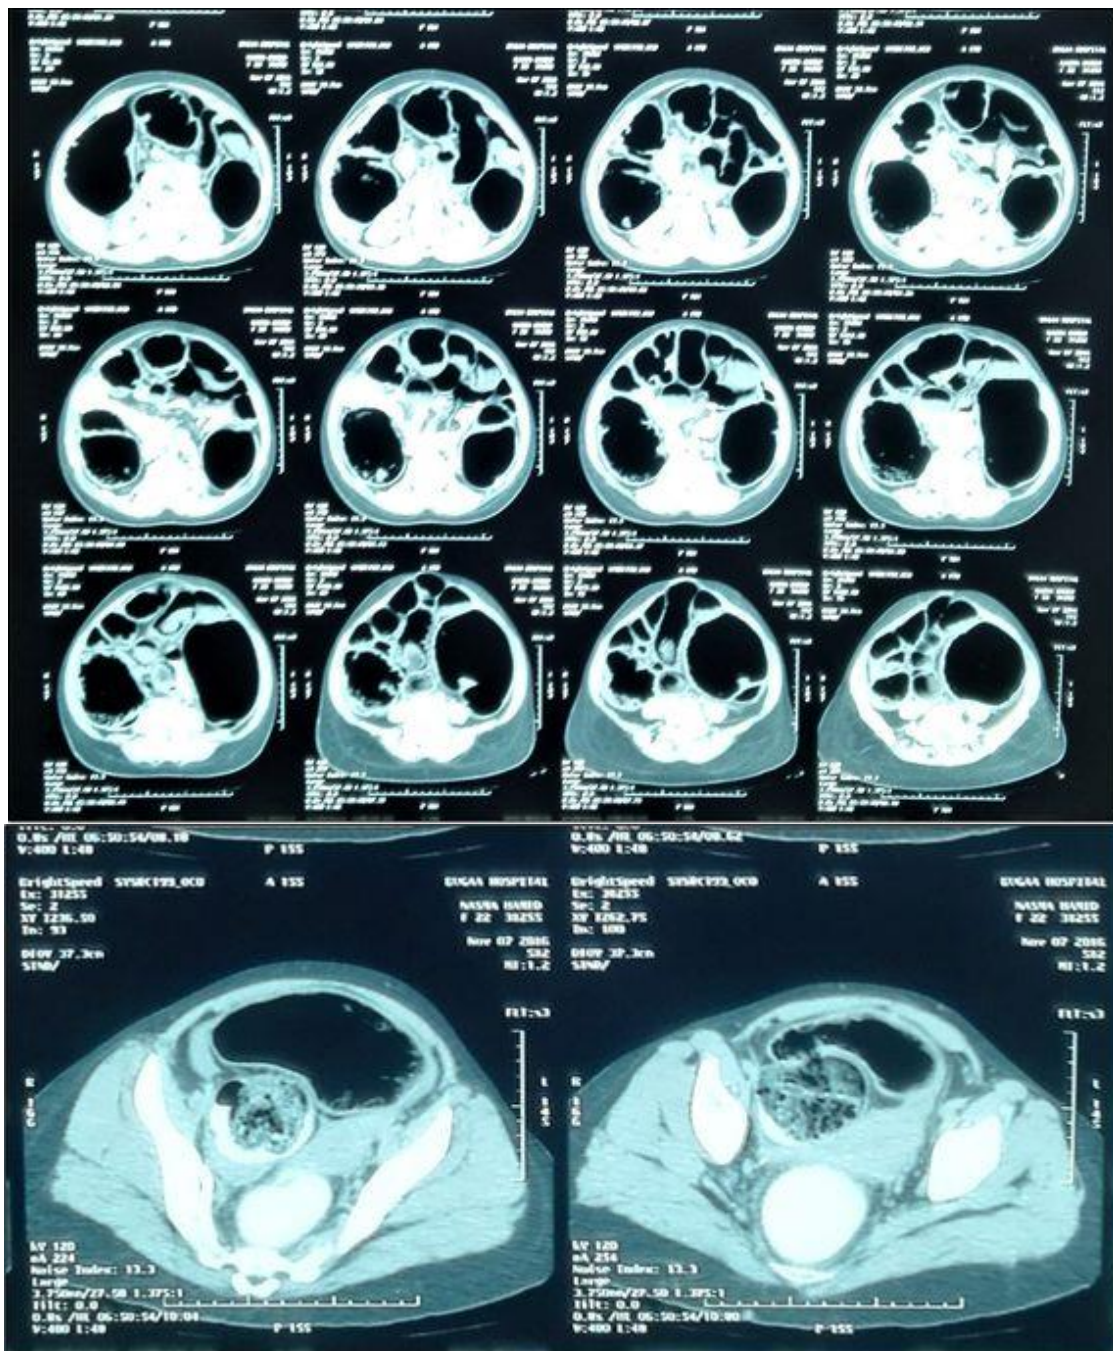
CT scan of the abdomen shows a dilated colon with distal sigmoid intra luminal obstructing lesion.
